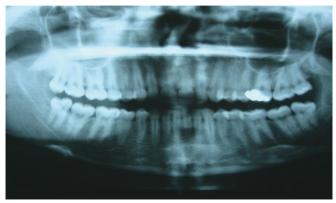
The panoramic radiography of the same patient.
